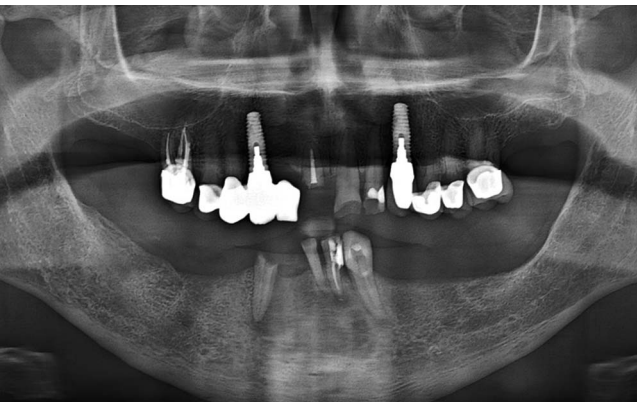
Preoperative panoramic radiograph demonstrating terminal dentition in the maxilla and mandible. The patient presents with multiple failing restorations, root canal-treated teeth with poor prognoses, and previously placed implants.
